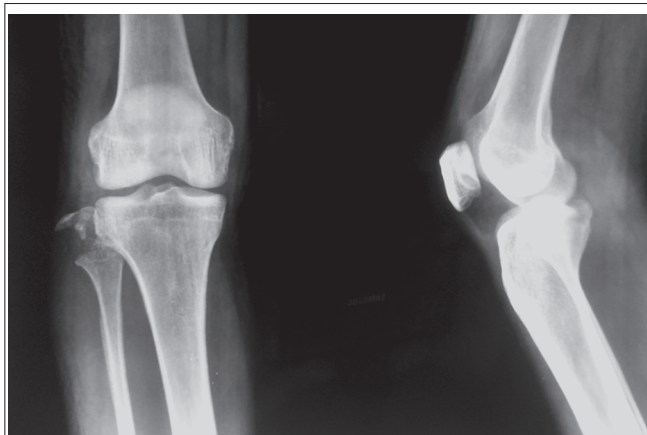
Pre-operative X-ray shows avulsion fracture of the fibular head without dislocation of the knee joint.
